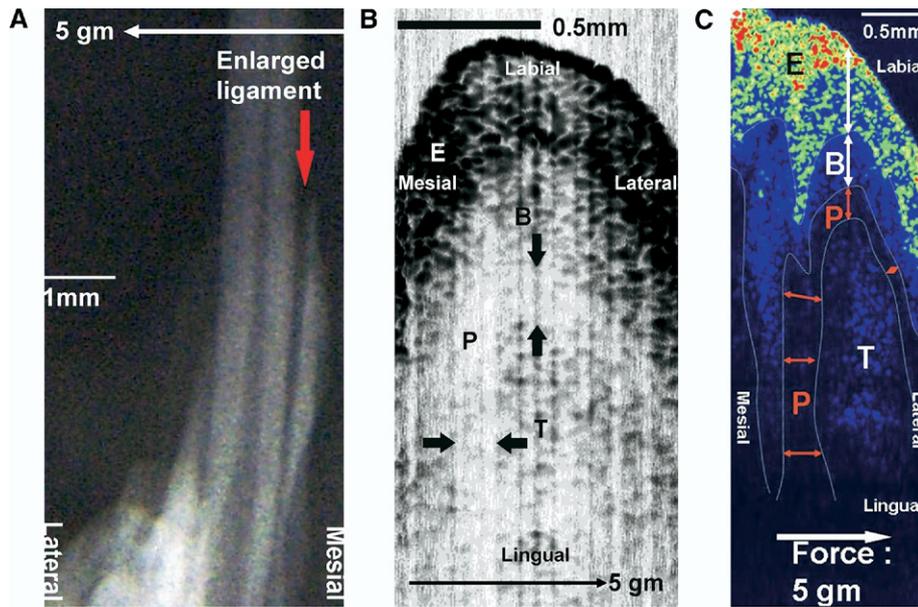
Images of a PDL at 5 gm. A, Radiograph; *white arrow* shows direction of force. B, OCT; more enlarged ligament space can be identified (between *black arrows*). C, Logging OCT; dynamic figures of ligament can be seen (*red arrows*).
